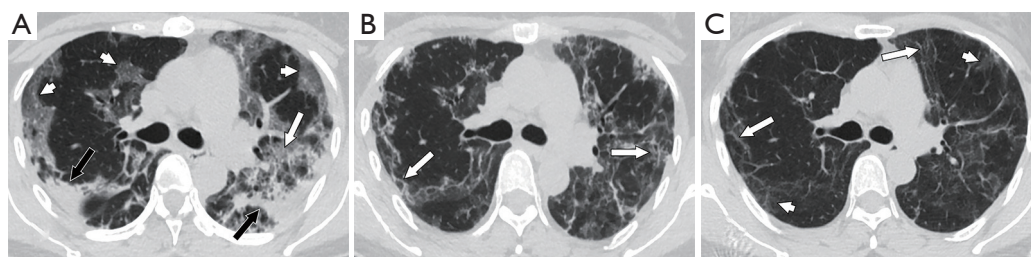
Thin-slice CT scan of a 40-year-old woman with COVID-19 with dyspnea after discharge (A-C obtained at 23, 70 and 254 days after onset, respectively). In the peak period, consolidation (black arrows), GGOs (white arrowheads) and crazy-paving patterns (white arrow) were observed bilaterally (A). At discharge, most areas of consolidation and the crazy-paving pattern had been absorbed, but reticulations (white arrows) had increased significantly (B). Only reticulations (white arrows) and small areas of ground-glass opacities (GGOs, white arrowheads) remained at follow-up (C). CT, computed tomography; COVID-19, coronavirus disease 2019; GGOs, ground-glass opacities.
